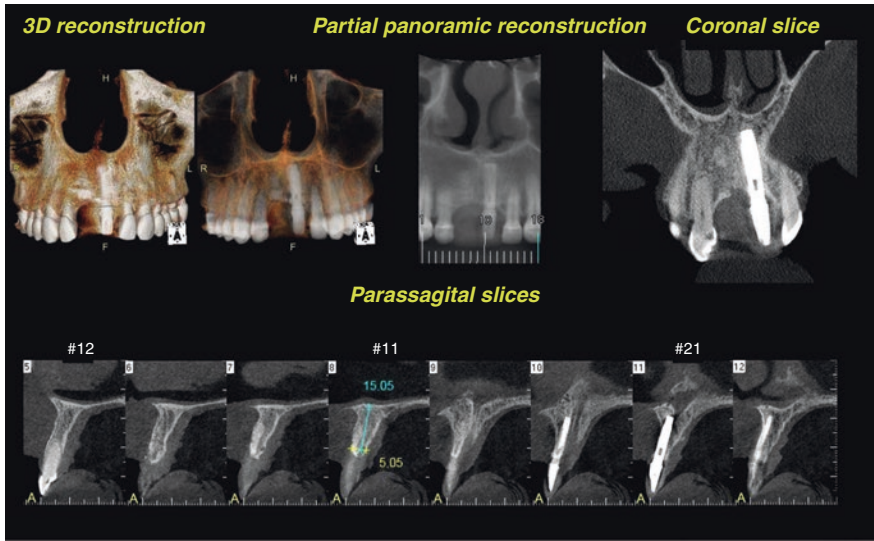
Example of a CBCT 2D template used for implant planning
